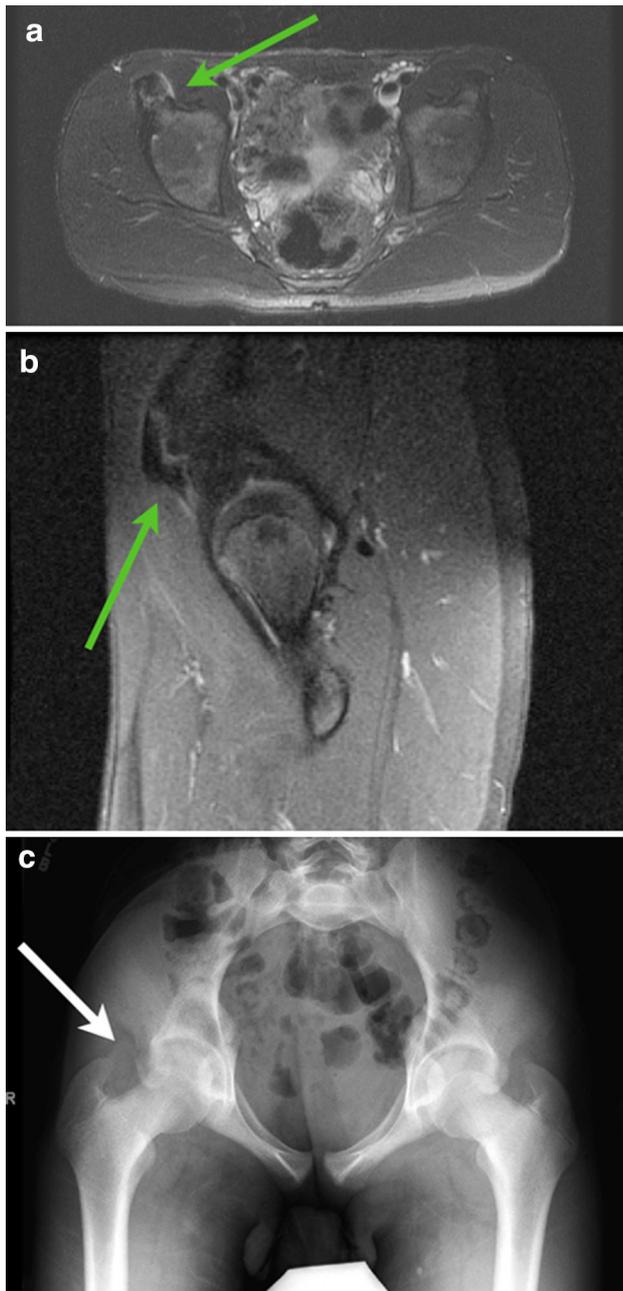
Diagnosis: avulsion fracture. A 15-year-old male with acute pain at his right anterior inferior iliac spine after a kicking a soccer ball. An axial T2 fat-saturation sequence of the pelvis (a) and sagittal proton density fat-saturation sequence of the right hip (b) reveal an avulsion fracture of the right anterior inferior iliac spine (green arrows), as shown by apophyseal displacement and edema at the physis extending along the ilium. Subsequently, radiographs of the pelvis were obtained, with the avulsion fracture of the anterior inferior iliac spine (white arrow) best shown on an inlet view of the pelvis (c) (Color figure online)
